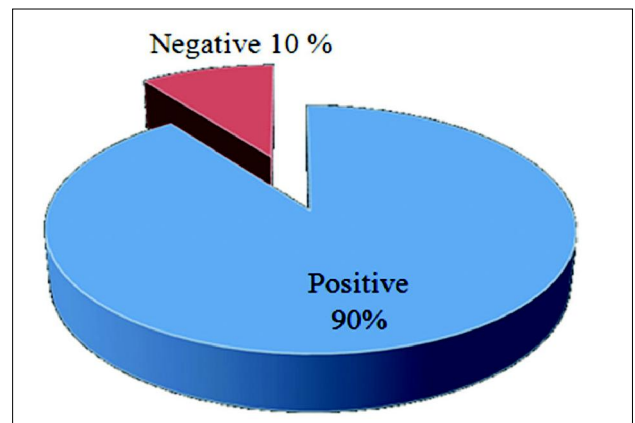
Pie chart for chest X-ray findings
